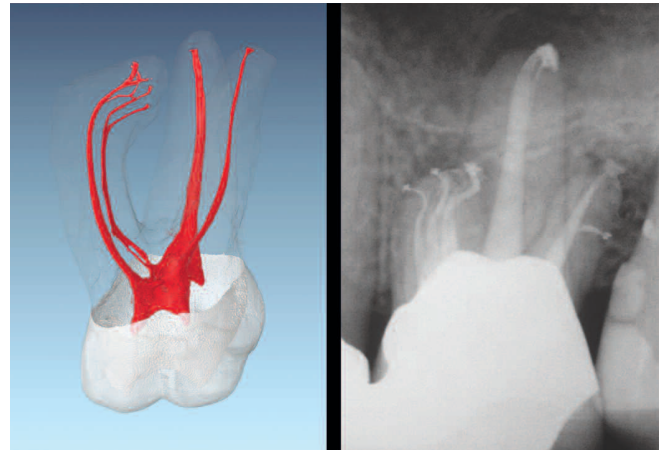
Left: A μ CT image of a maxillary molar (Courtesy of Dr. Frank Paque; Zurich, Switzerland). Right: This film demonstrates challenging endodontic anatomy and the clinical importance of treating root canal systems.
